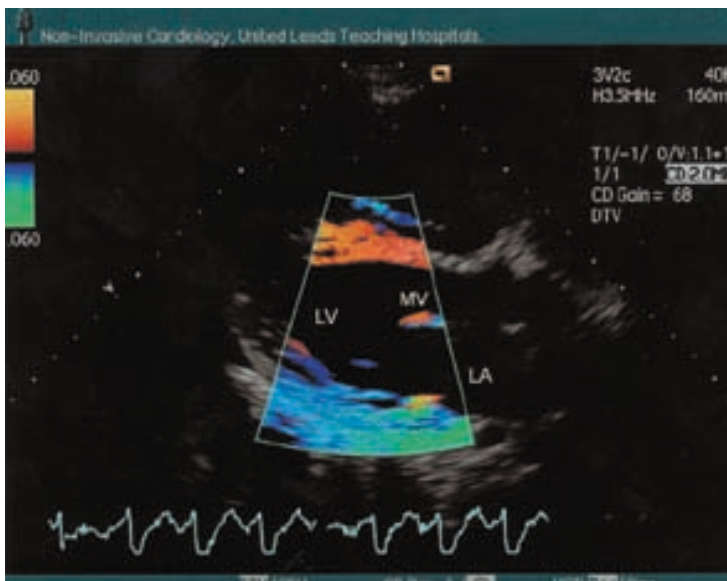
Doppler tissue images of a normal subject demonstrating movements of the mitral valve, the septum and the posterior left ventricular wall. LA = left atrium; LV = left ventricle; MV = mitral valve.
